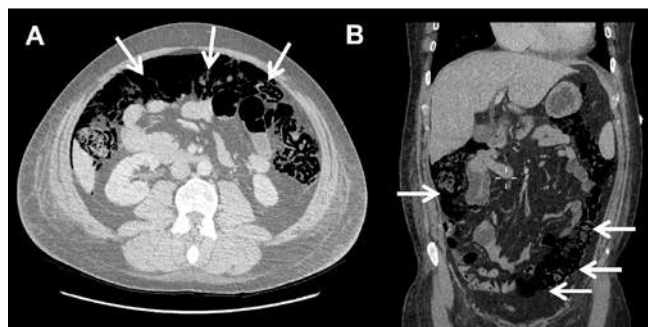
Axial (1A) and coronal (1B) views from a contrast computed tomography scan of the abdomen demonstrating extensive pneumatosis intestinalis of the large bowel. The dark areas (arrowed) represent extensive submucosal gas.
